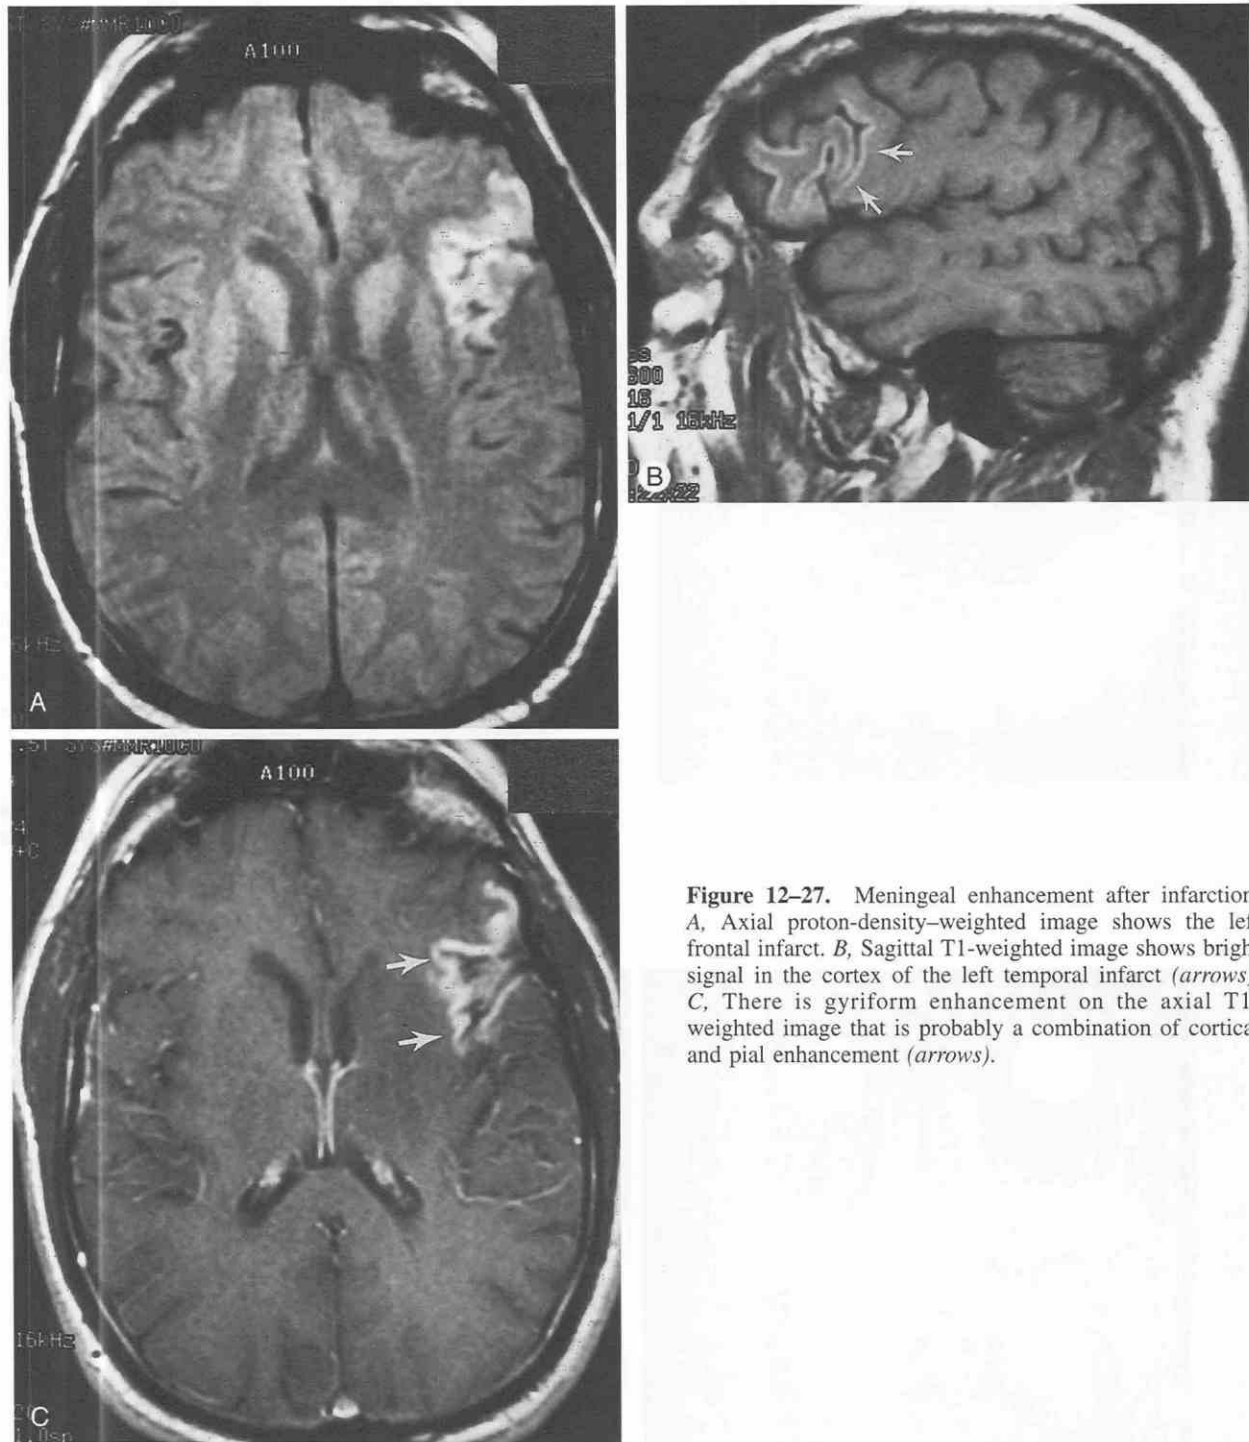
Meningeal enhancement after infarction. A, Axial proton-density-weighted image shows the left frontal infarct. B, Sagittal T1-weighted image shows bright signal in the cortex of the left temporal infarct (arrows). C, There is gyriform enhancement on the axial T1-weighted image that is probably a combination of cortical and pial enhancement (arrows).
